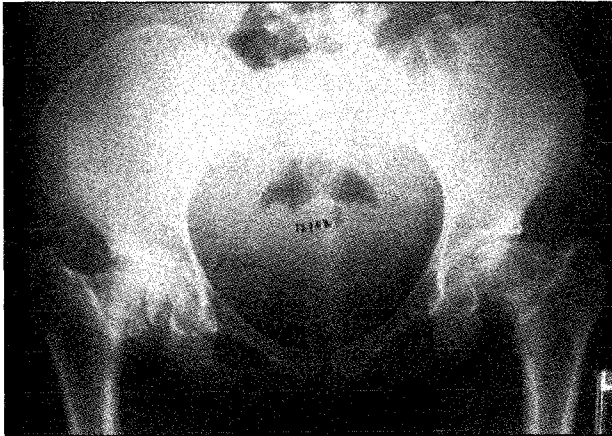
(Case 12). Bilateral SCFE presented at the age of 12 years. The radiograph at the age of 17 years and she remained asymptomatic
